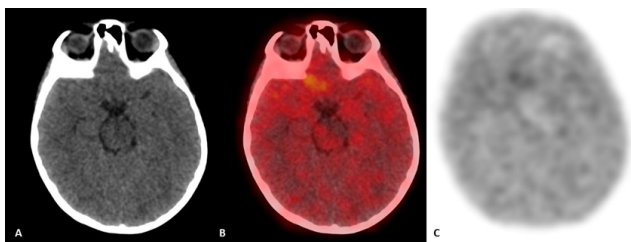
F-DOPA PET CT, Plain CT; A: Fusion PET CT; C: showing increased dopaminergic activity in right basi-frontal region; B: Dedicated DOPA Brain PET image showing increased dopaminergic activity in right basi-frontal region.
